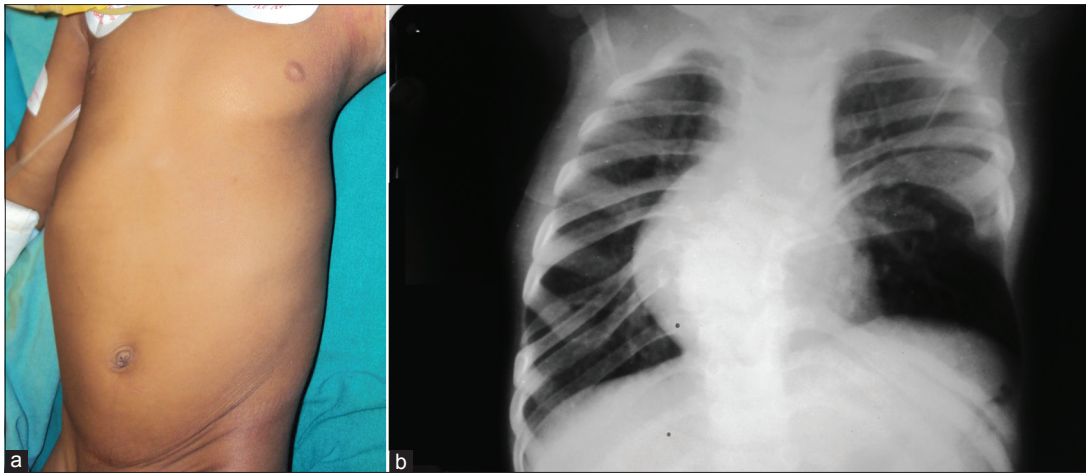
(a) Patient C having left-sided chest defect; (b) chest radiograph of patient C showing rib defect on the left side
